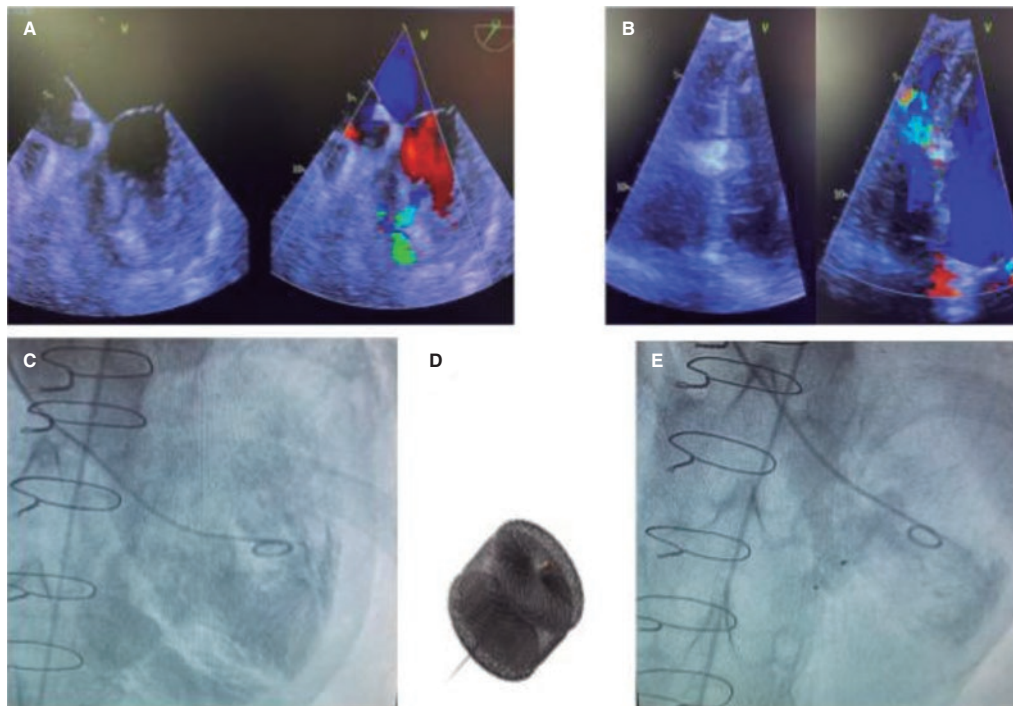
Postoperative non-restrictive residual ventricular septal defect, (A) and presence of a small residual ventricular septal defect after closure with the Amplatzer device (B) as seen on the transthoracic echocardiography. Angiography shows the presence of a significant left-to-right shunt (C) significantly reduced after percutaneous closure (E) with an Amplatzer-AVPII device (D).
